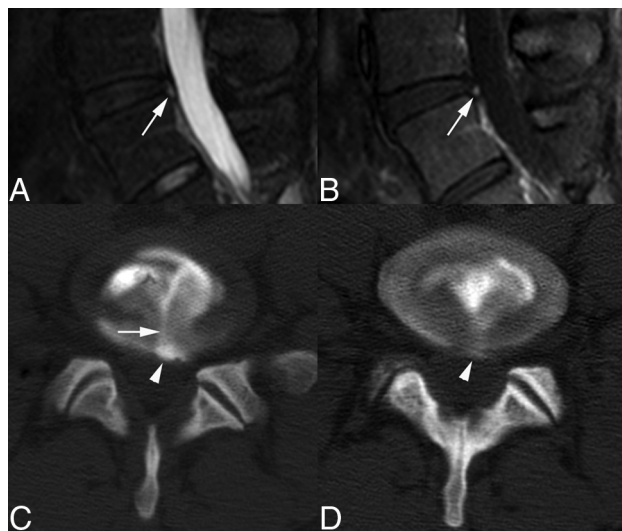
A 29-year-old woman with complex LBP and leg pain (most severe VAS = 10/10; preprocedural VAS = 5/10) with prior L5–S1 discectomy. Concordant pain was provoked at L4–5 (VAS = 10/10). A, Sagittal T2-weighted sequence demonstrates a small annular fissure along the posterior annular margin (arrow), judged Grade 4 by consensus. B, Sagittal postcontrast T1-weighted sequence demonstrates enhancement in the annular fissure (arrow). C, Axial postdiscogram CT image demonstrates a full-thickness radial annular fissure (arrow) projecting into a small peripheral concentric annular fissure (arrowhead). D, Axial postdiscogram CT image demonstrates the posterior annular margin at the level of the peripheral concentric annular fissure (arrowhead), which corresponds to the HIZ identified on the T2-weighted sequence and EAF region demonstrated on the postcontrast T1-weighted sequence.
